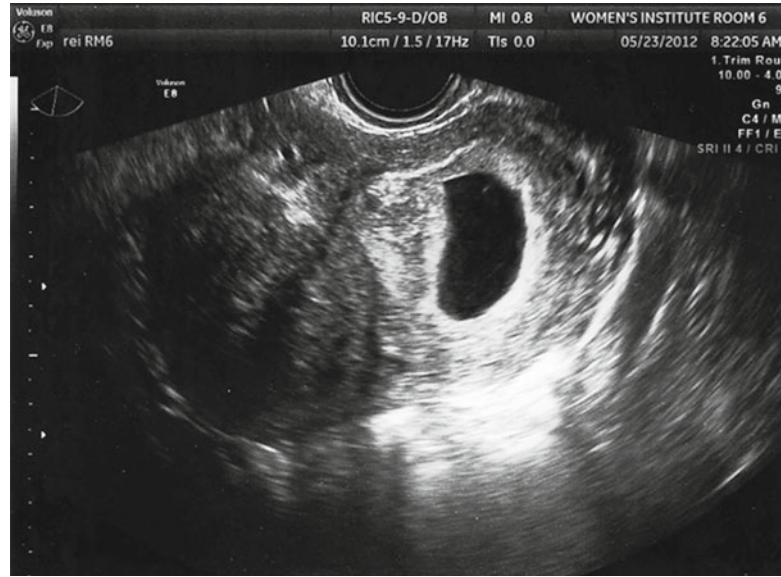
Transvaginal ultrasound demonstrating subserosal fibroid
